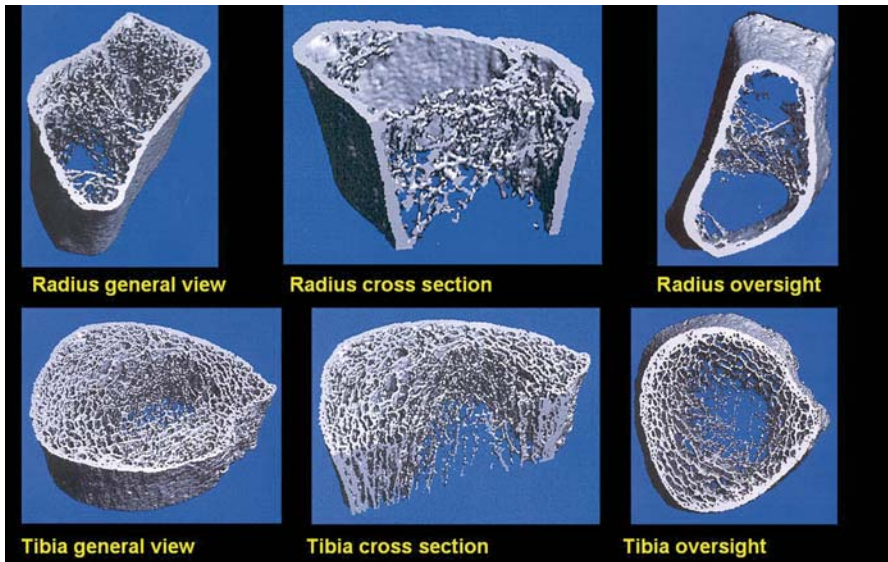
The Xtreme-CT: 3D structure presentations at various views of osteoporotic distal extremities
